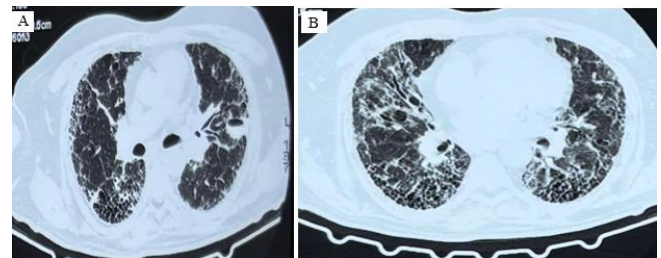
A,B: CT Chest: Bilateral honeycombing with traction bronchiectasis noted in both lung fields. Evidence of left thick walled cavity in upper lobe
